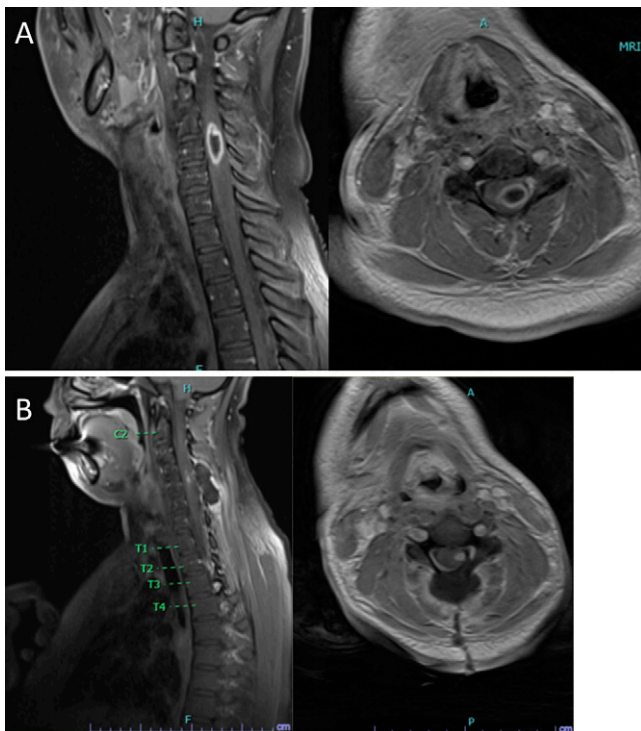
Preoperative (A) and postoperative (B) sagittal (left) and axial (right) postcontrast T1-weighted MRI demonstrating successful drainage of the intramedullary abscess resulting in a small T1 contrast-enhancing lesion.
